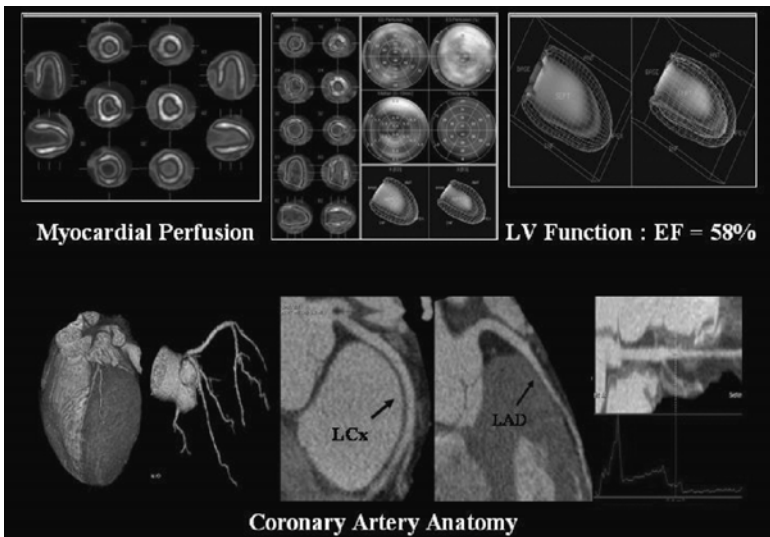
In a non-invasive, single setting, combined PET/CT demonstrates myocardial perfusion, evaluation of left ventricular function, and coronary artery anatomy, which can be displayed in various planar and three-dimensional displays.
